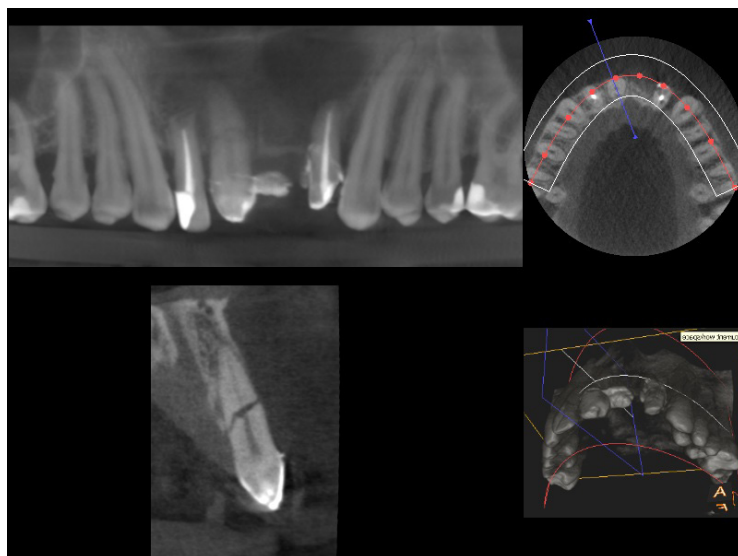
CBCT of a patient with radicular fracture – left superior incisor (anterior, superior and lateral view), 3D reconstruction
